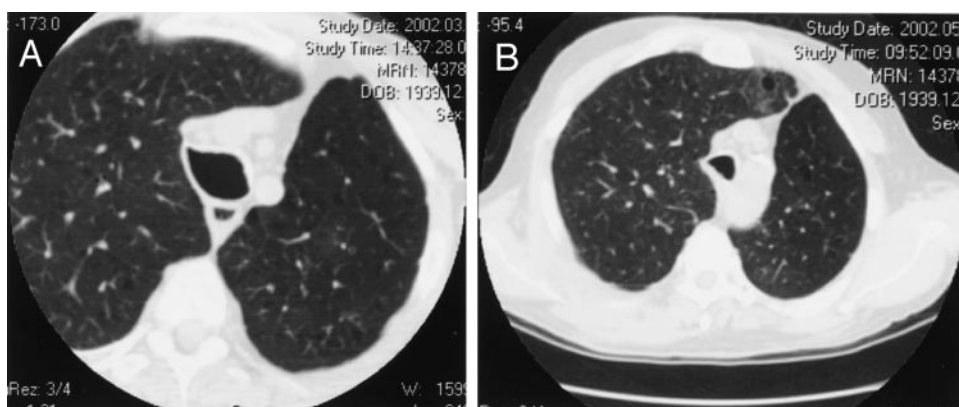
CT scan images of a patient with TM. *Left, A:* prior to surgical intervention. *Right, B:* after surgical tracheoplasty, demonstrating a trachea that is normal in shape and size.
